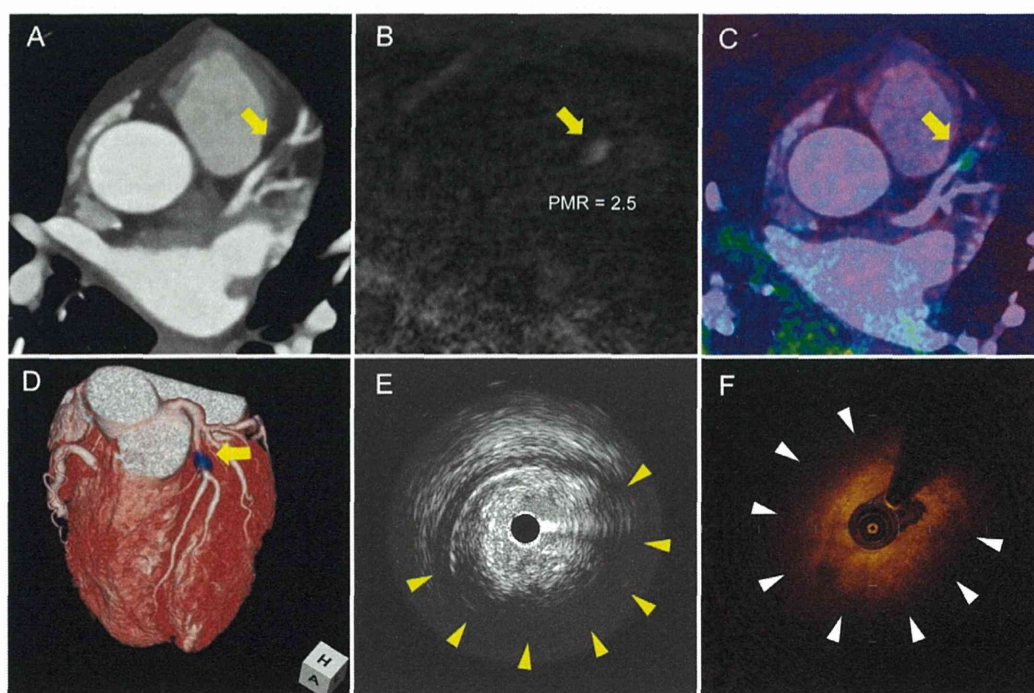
Computed tomography angiography (CTA) and magnetic resonance imaging of the coronary artery prior to percutaneous coronary intervention. (A) Coronary CTA showing a lesion of the left anterior descending artery (LAD) with significant stenosis and positive vessel remodeling (yellow arrow). (B) Non-contrast T1-weighted magnetic resonance imaging (T1WI) at 3.0 T showing a high-intensity plaque with a plaque-to-myocardium signal intensity ratio (PMR) of 2.5 in a LAD lesion, which corresponds to a coronary plaque detected on CTA (yellow arrow). (C) Two-dimensional fusion image between coronary CTA and non-contrast T1WI at 3.0 T (Ziostation 2; Ziosoft, Tokyo, Japan). (D) Three-dimensional fusion image between coronary CTA (volume-rendered image) and non-contrast T1WI at 3.0 T. (E) Intravascular ultrasound (View It, Terumo, Tokyo, Japan) showing the heterogeneous appearance of a large intimal plaque and low-echogenicity region in the deeper intima with remarkable attenuation (yellow arrowheads). (F) Optical coherence tomography (ILUMIEN OPTIS, St. Jude Medical Japan, Tokyo, Japan) showing an extensive signal-poor region with low backscattering and a lipid arc of 286° (white arrowheads).
